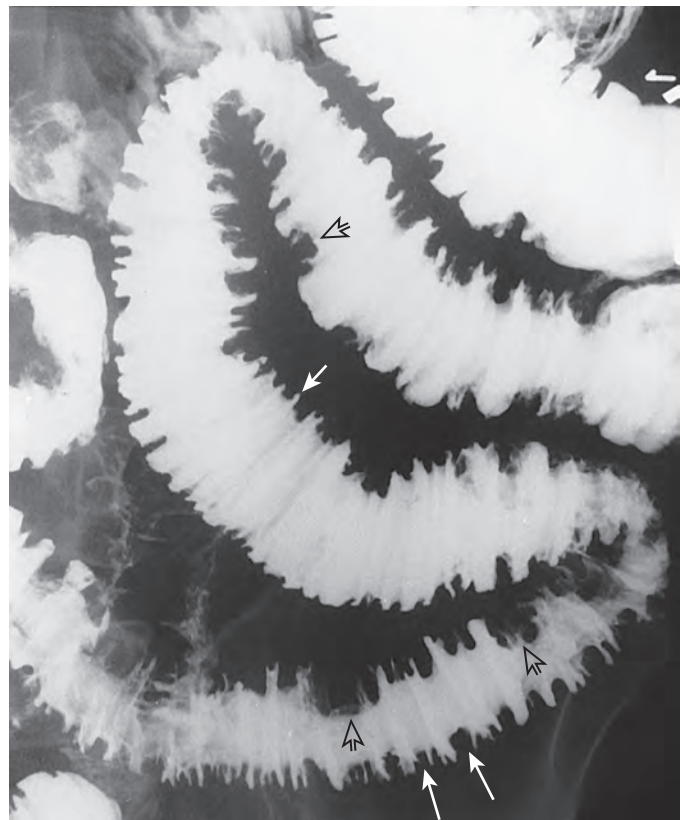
Thumbprinting. Polypoid projections (*open arrows*) are seen along the mesenteric border of the ileum. Note the abrupt angulation of the protrusions and smooth surfaces, radiographic findings typical of submucosal lesions. This thumbprinting reflects submucosal hemorrhage in a patient with small bowel vasculitis. Also note the smooth, straight, parallel folds (*long white arrows*)—stack of coins appearance—and interspace spikes (*short white arrow*).
